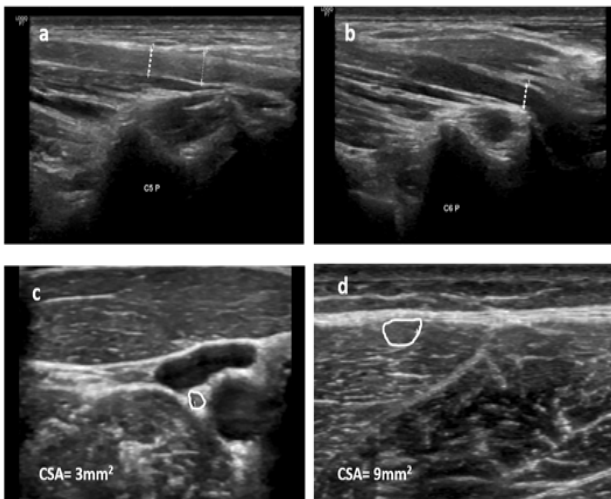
Ultrasonographic image of the right peripheral nerves at the C5 root (a) with a diameter of 2.5mm, C6 (b) with a diameter of 4.7mm, the vagus nerve (c) and the sural nerve (d). UPSS - B score = 0 + 1 + 0 = 1. UPSS - C score = 1.
